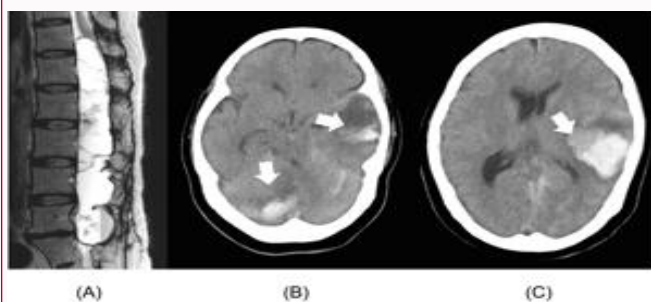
A 56-year-old female patient with intradural extramedullary tumor. A) Preoperative MRI. T2-weighted sagittal MRI shows a huge intradural extramedullary tumor extending from T12 to L5. B,C) Computed tomogram the day after surgery. Intracranial hemorrhage is seen in the right cerebellar hemisphere (B, arrow), tentorium cerebelli, and the left temporal lobe (B, C, arrows).
